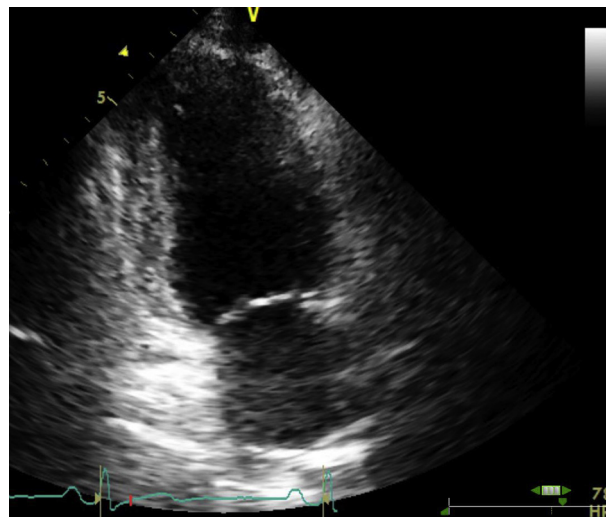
Apical two-chamber view after immunosuppression therapy revealing normal left ventricular size and normal left atrial size.
